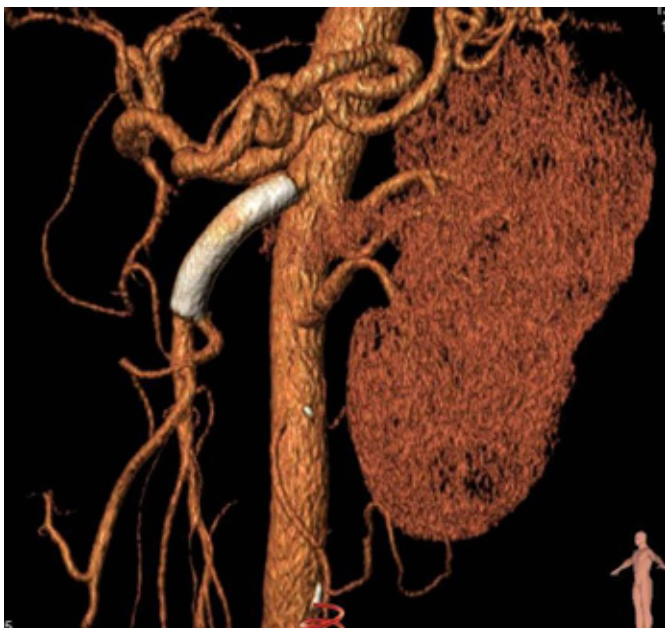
The first patient that underwent endovascular treatment, completed 5 years of uneventful follow-up. CTA revealed adequate stent position, SMA patency and dissection disappearance.
